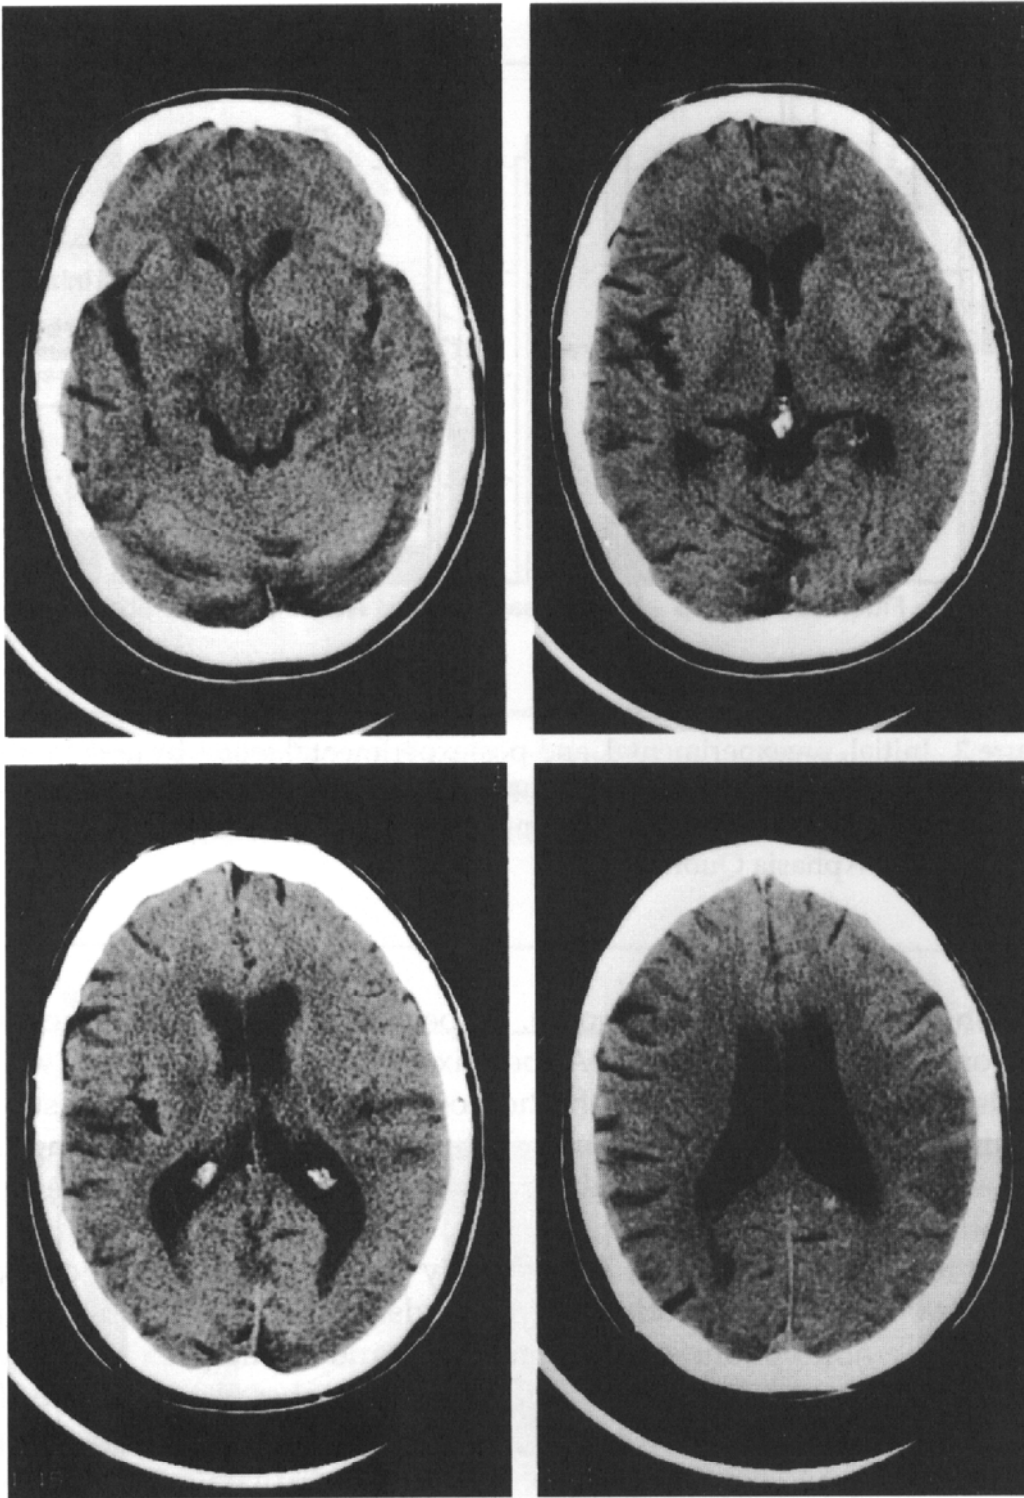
CT scan results demonstrating site of lesion in experimental subject.
